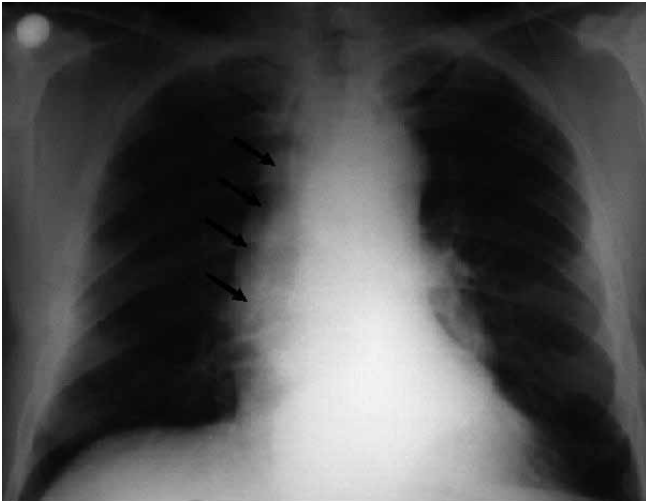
Pre-operative chest X-ray showing a dilated and mildly calcified aortic arch (arrows).
